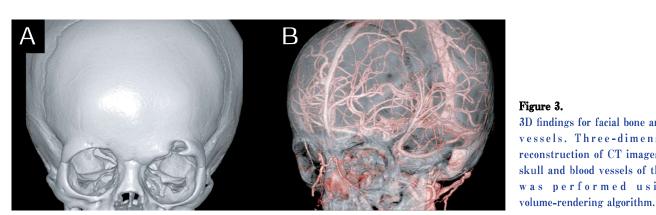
3D findings for facial bone and blood vessels. Three-dimensional reconstruction of CT images of the skull and blood vessels of the head was performed using a
